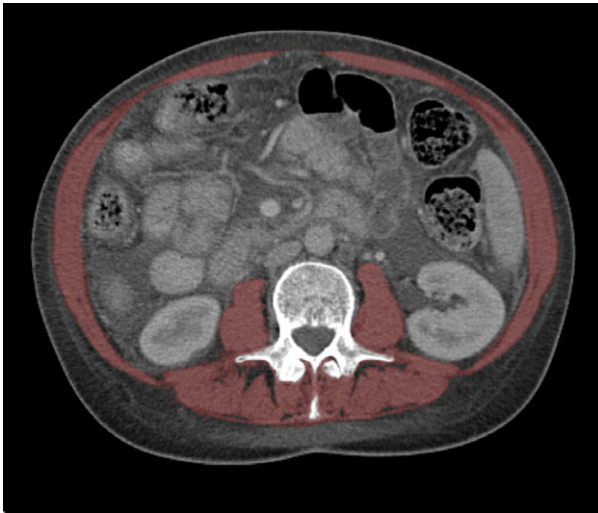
Cross-sectional skeletal muscle mass measurement. Example of a measurement of skeletal muscle mass on CT. The cross-sectional skeletal muscle area (129.74 cm²) is depicted of a 60-year-old female with a body mass index of 22.1 kg/m². With a body height of 1.74 m this resulted in a skeletal muscle index of 42.9 cm²/m². Consequently, this patient was considered not to have sarcopenia.
